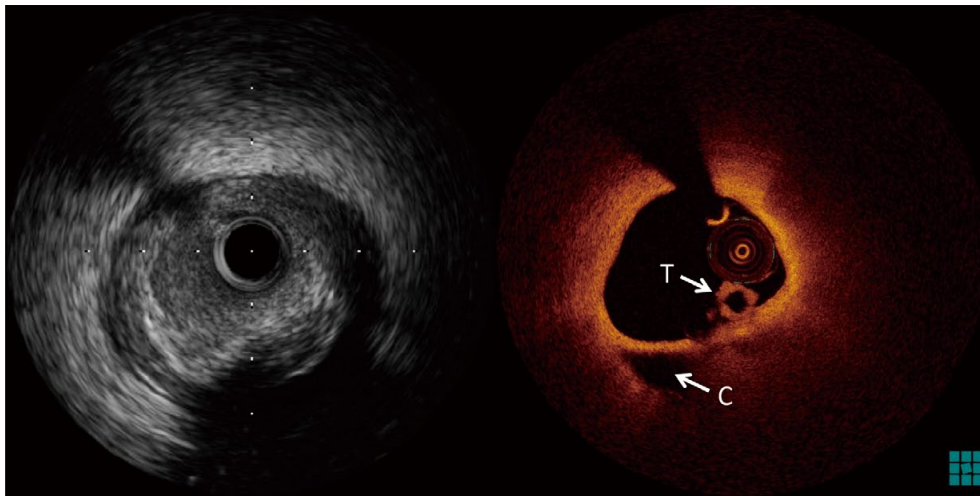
Comparison of intravascular ultrasound (IVUS) and optical coherence tomography (OCT). Matched images of IVUS (Left) and OCT (Right) of the culprit lesion in a patient with ST-elevation myocardial infarction. OCT clearly visualizes white thrombus (T) attached to the surface of a lipid-rich plaque with cavity (C), which can not be delineated by IVUS.
